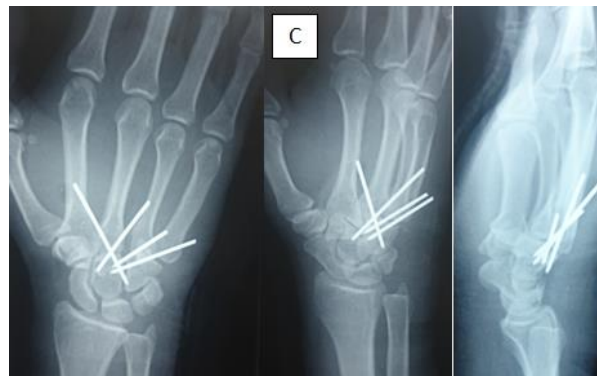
Figure C shows the post-operative plain radiographs of the right wrist with the affected CMCJs properly reduced and stabilized.
